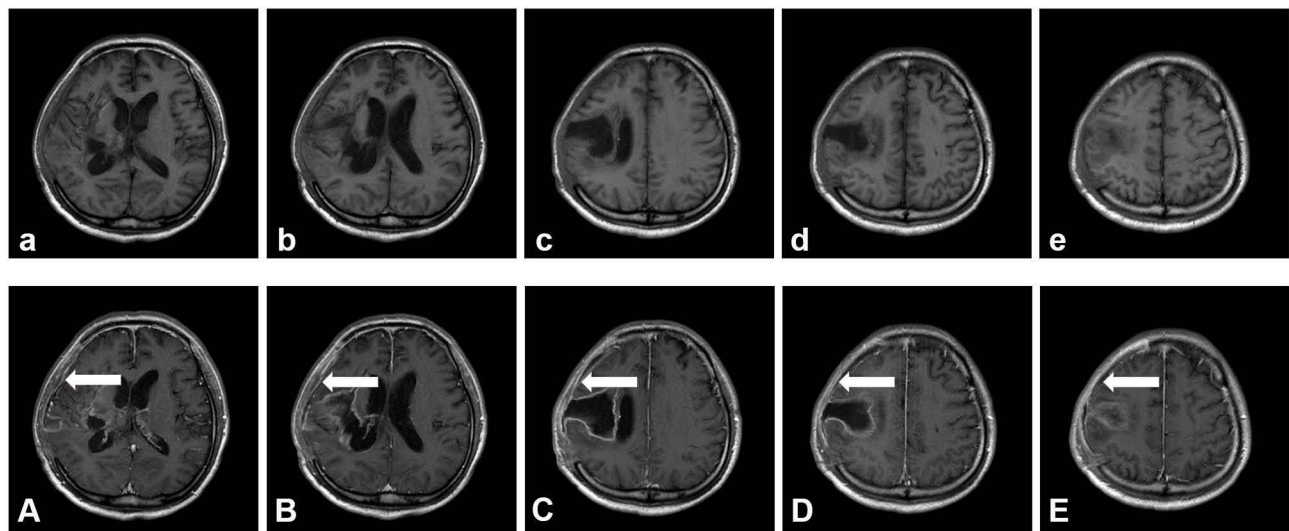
Brain MRI images on August 25 demonstrated post-cerebral hemorrhage in the right frontal lobe, temporal lobe, right basal ganglia, and thalamus, and the softening of the focus (a–e). The marginal enhancement of the operative area was considered to be a consequence of postoperative repair changes. The meninges indicated with the arrow was located in the right temporal region were enhanced and was considered to be inflammatory. Epidural marked curve demonstrated significant contrast enhancement following intravenous gadolinium administration (A–E) and there was slight subdural effusion in the right frontal area.
